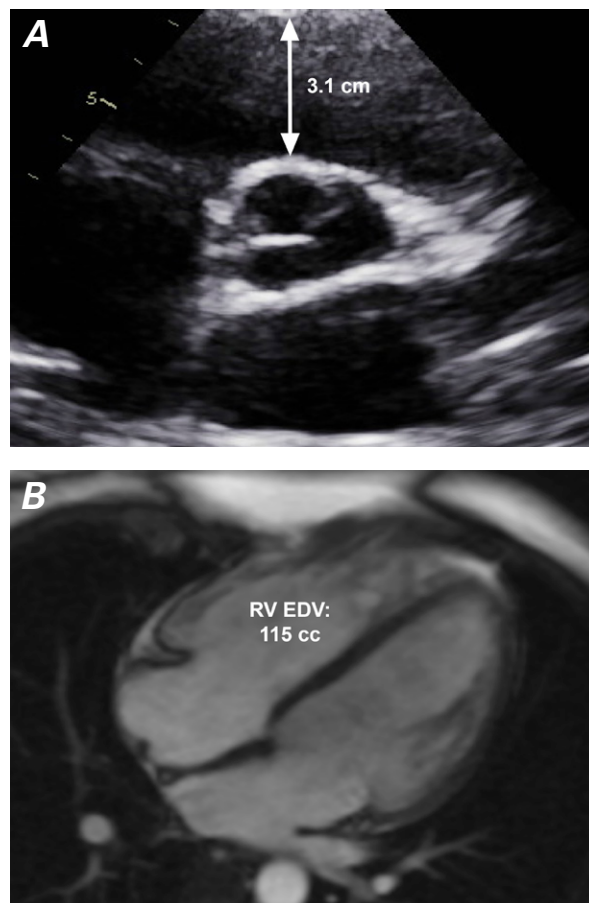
A) Two-dimensional transthoracic echocardiogram (short-axis linear view) shows the right ventricular outflow tract dimension. B) Cardiac magnetic resonance image (4-chamber view) shows a structurally intact right ventricle (RV) and the calculated end-diastolic volume (EDV).
